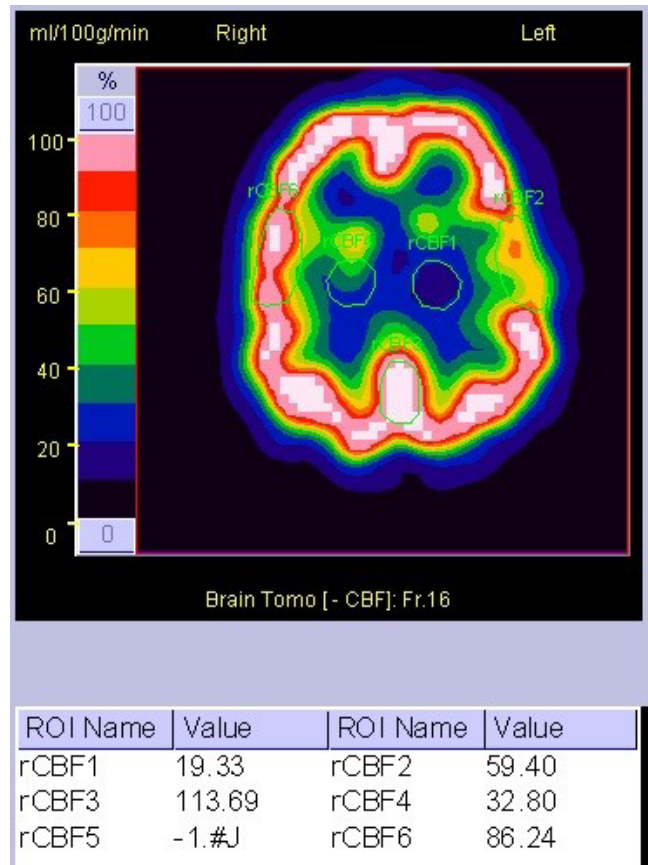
Semi-quantitative analysis of a SPECT transverse section image, outlining the ROI counts of each lesion site and the corresponding contralateral s, as well as the ROI counts of the cerebellar region.
